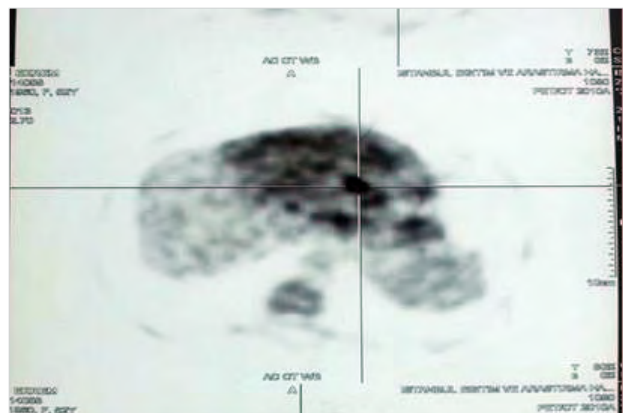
PET CT findings compatible with cholangiocellular carcinoma of the second patient.
